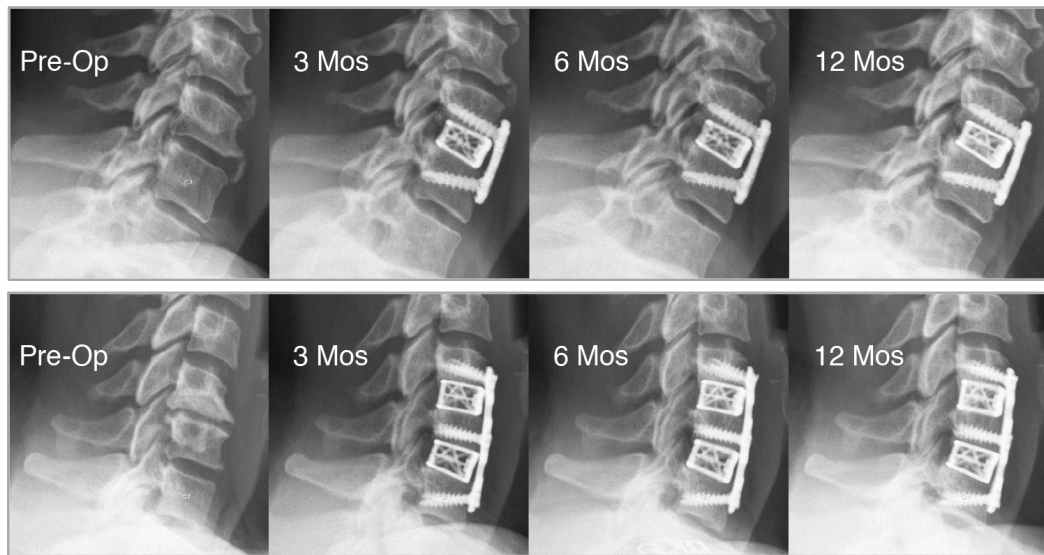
Radiographic examples of one- and two-level cervical fusion cases. The Pre-Op, 3, 6 and 12 month neutral-lateral radiographs show the increase in spacing between vertebral bodies that was achieved at the time of surgery, and the maintenance of this increased spacing over-time. Ingrowth of bone into and around the cage is also radiographically evident.
